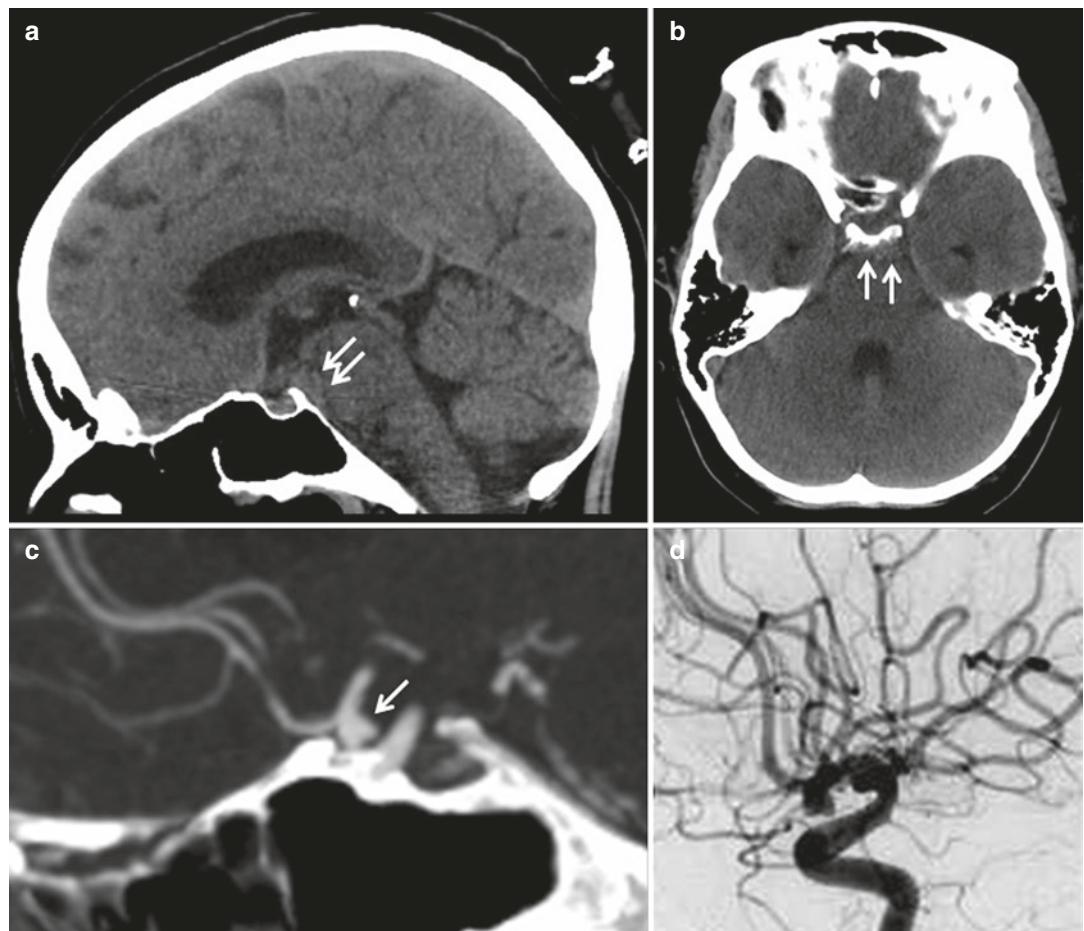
Sagittal (a) and axial (b) images of a non-contrast head CT in a 45-year-old woman with abrupt “worst” headache of her life 5 days prior show subtle subarachnoid hemorrhage in the preopticine and suprasellar cisterns (arrows). Given the delay in presenting to the ED, the blood in the subarachnoid space is isodense to the brain parenchyma. Sagittal image of a subsequent CTA
